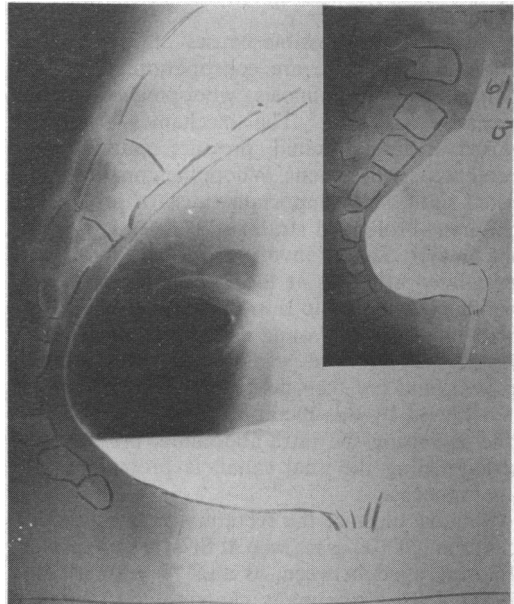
Contrast X-rays showing the pelvis of an adult (left) and a six-month old infant (right). Note increased curve of the adult sacrum
